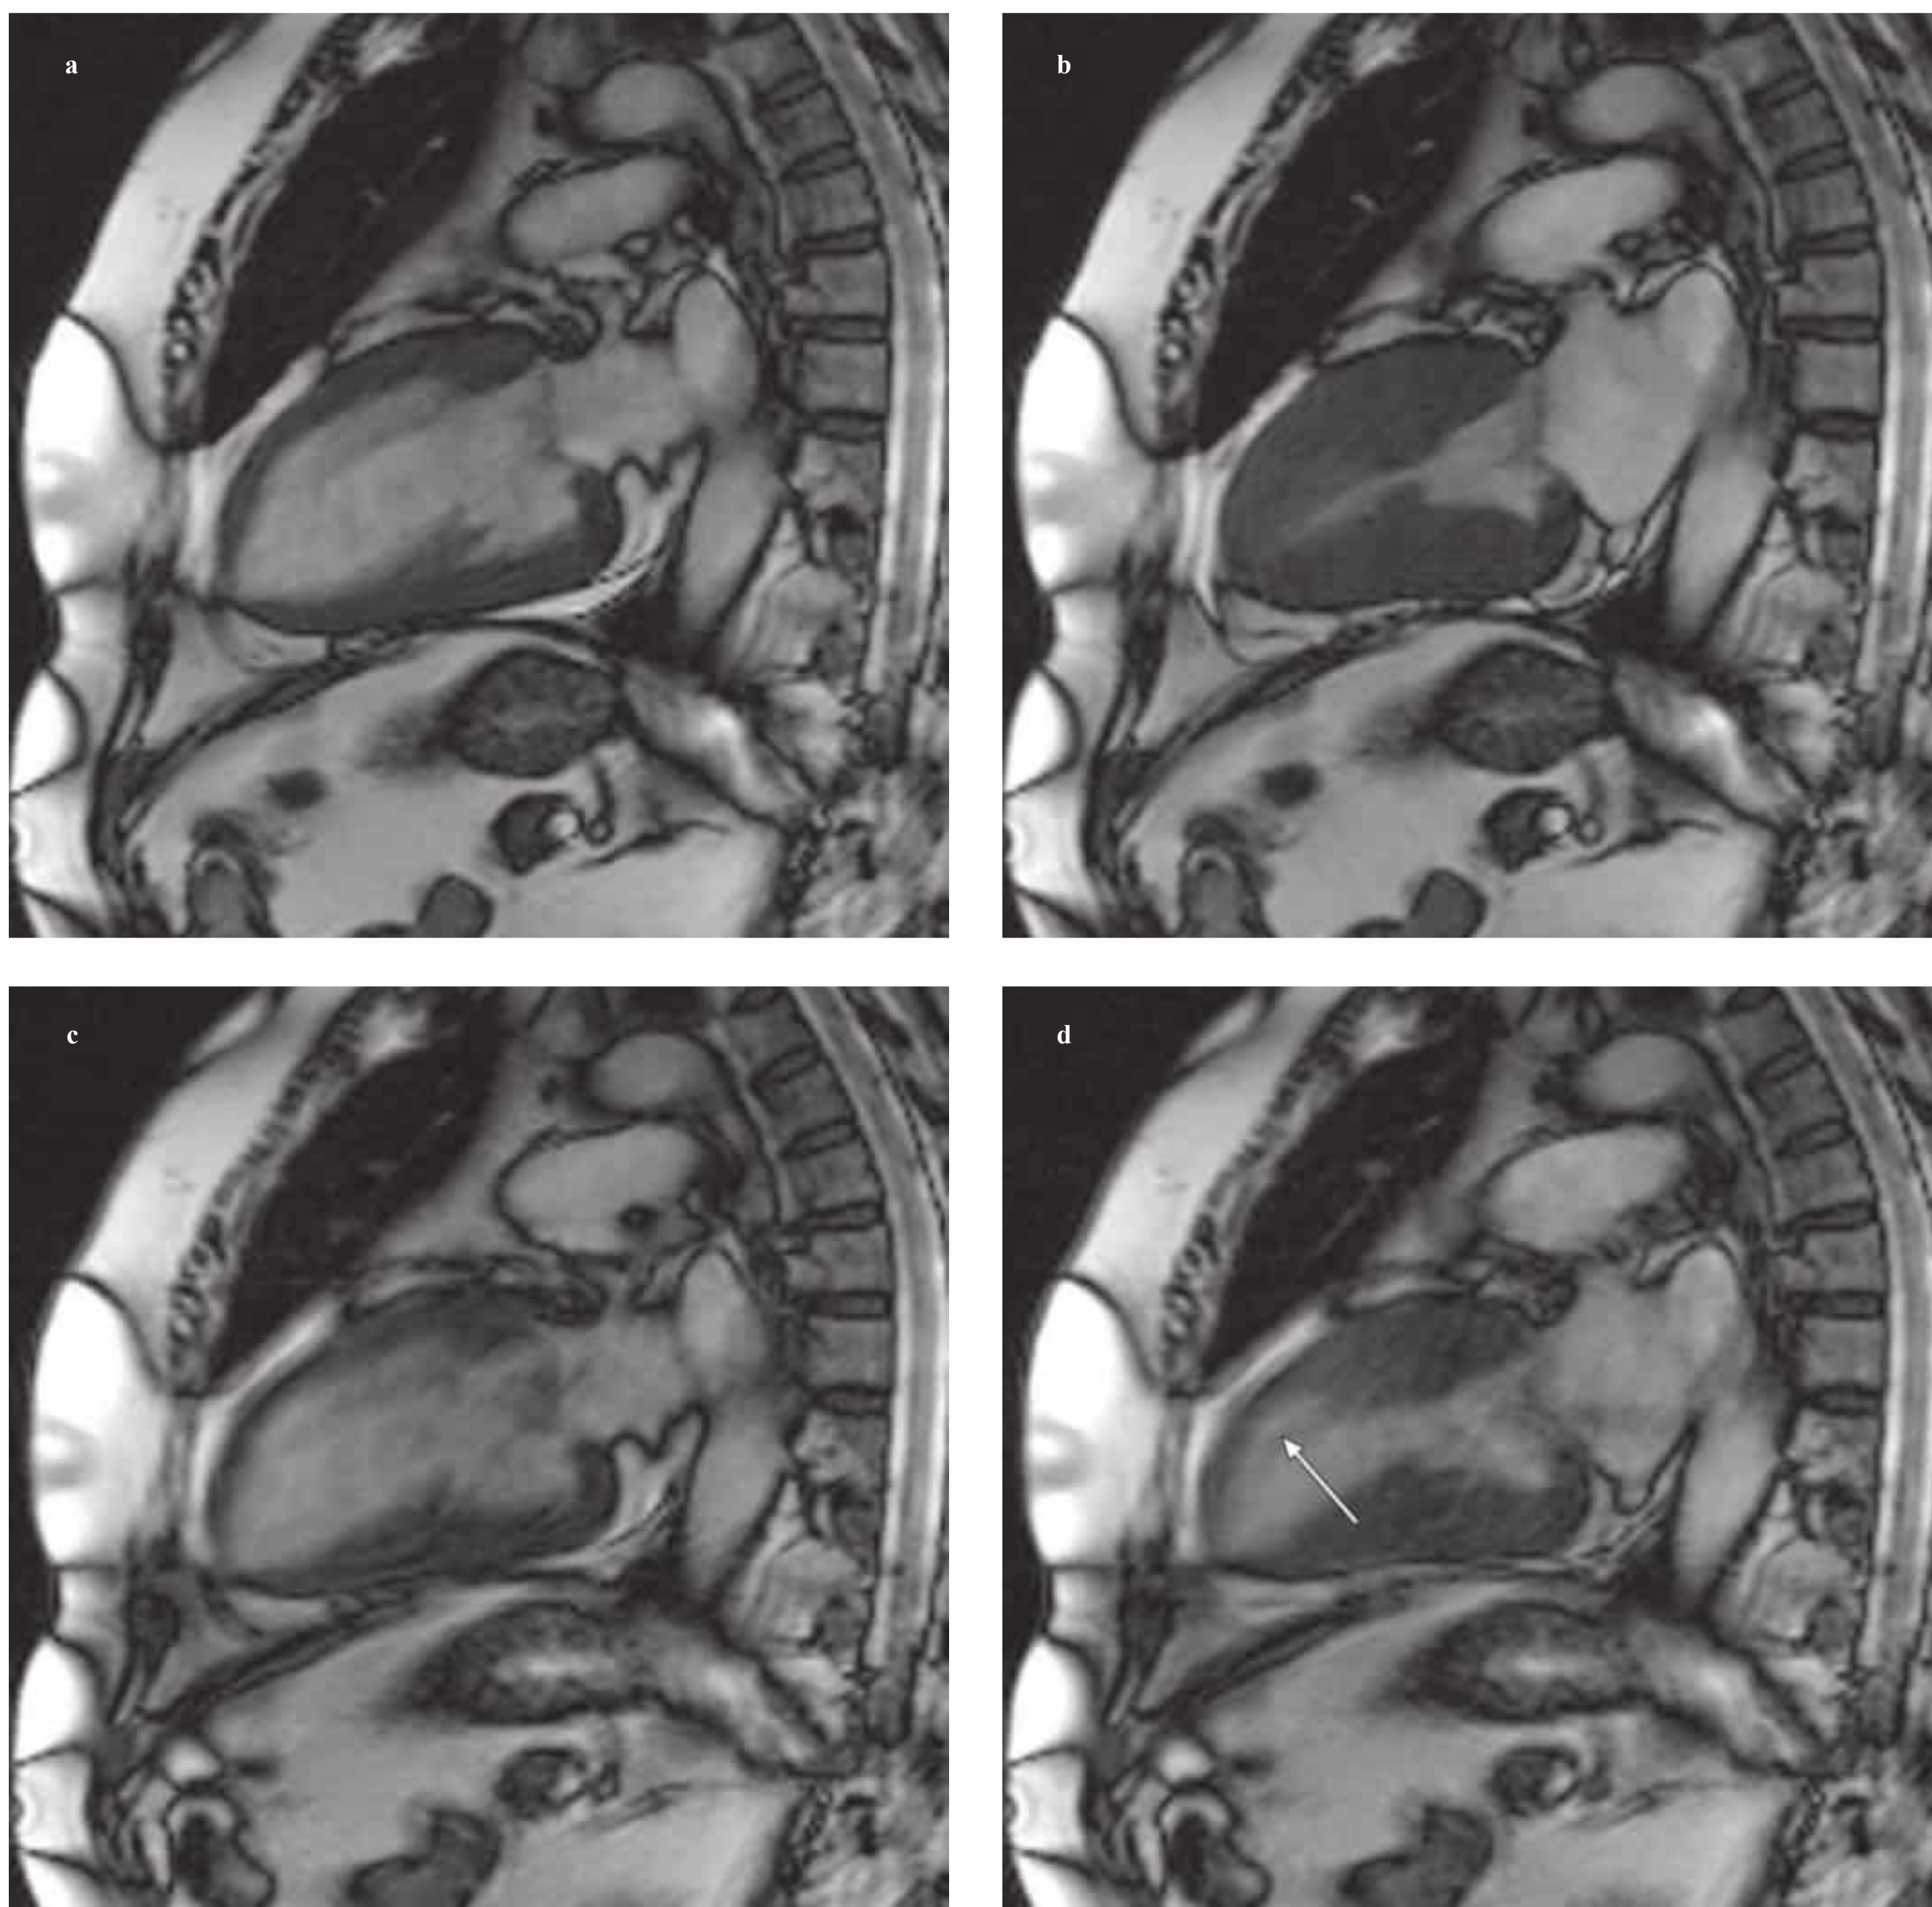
a–d Cine images (vertical long axis) from a stress MRI examination. The images in the left column (a, c) were acquired in diastole, the images in the right column (b, d) in systole. The upper images, acquired at rest, demonstrate normal wall motion with no evidence of circumscribed abnormalities. The lower
